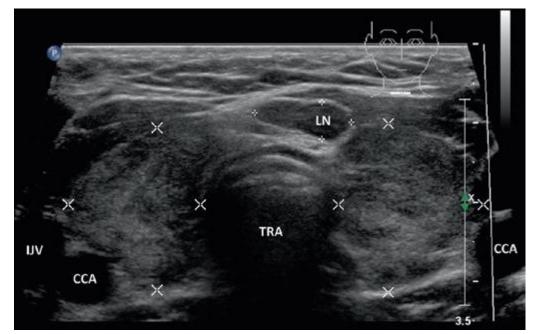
Ultrasound Appearance of Paratracheal Lymph Node (Level-VI), Delphian Lymph Node.
